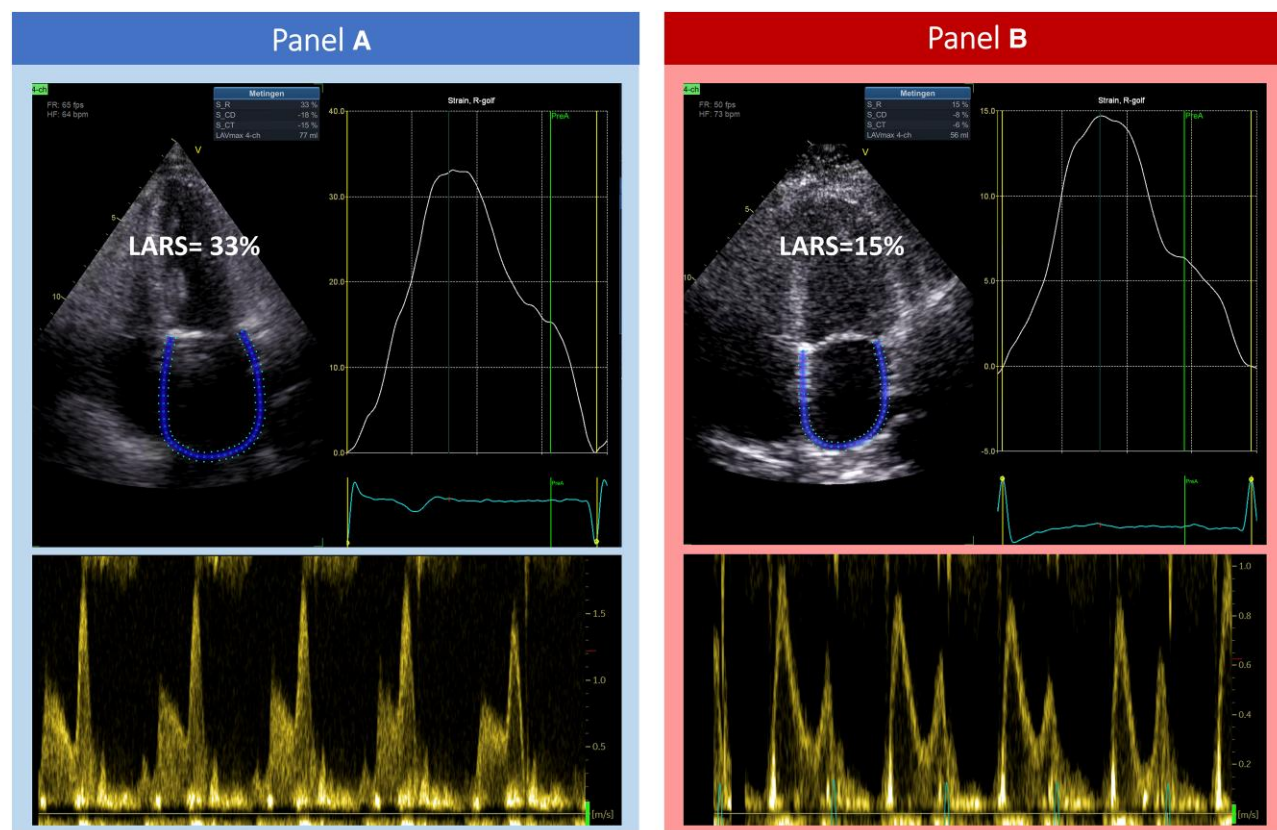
A demonstration of the acquisition of LARS in patients undergoing TAVI for severe aortic stenosis, with left atrial strain curves and corresponding transmitral pulsed wave Doppler flow. (A) A patient with Grade 0/1 LARS-DD (LARS 33%), who survived at long-term follow-up. (B) A patient with Grade 3 LARS-DD (LARS 15%). This patient did not survive at long-term follow-up. LARS, left atrial reservoir strain; LARS-DD, left atrial reservoir strain diastolic dysfunction; TAVI, transcatheter aortic valve implantation.
